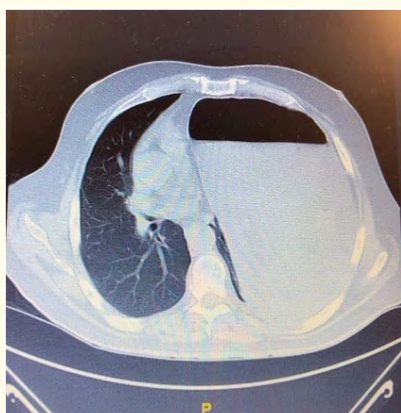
Computed tomography of abdomen shows distention of the stomach due to air, with herniation, compromising mediastinal structures.
